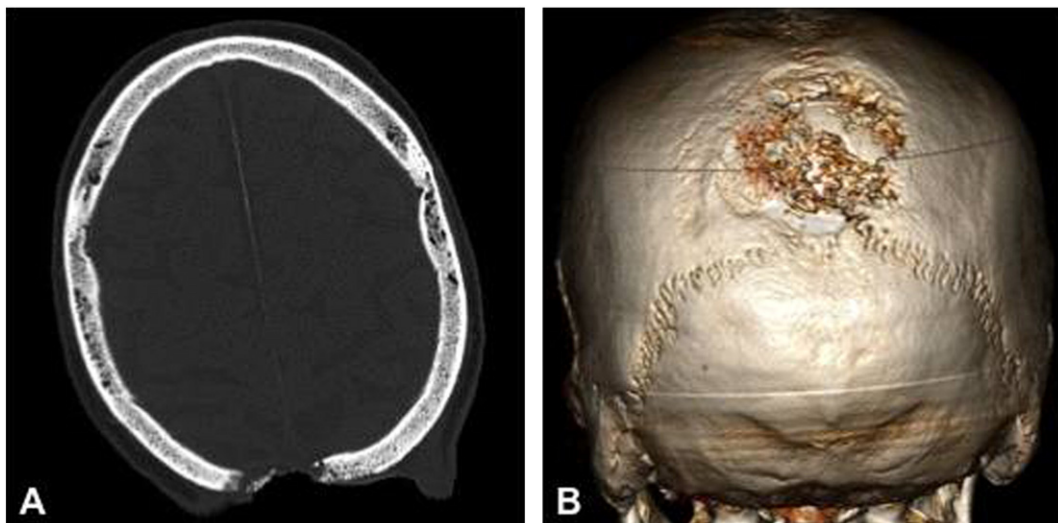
A, Pre-operative CT scan showing the bone defect in the middle parieto-occipital region. B, 3-dimensional CT scan depicting the bone defect over the vertex.
